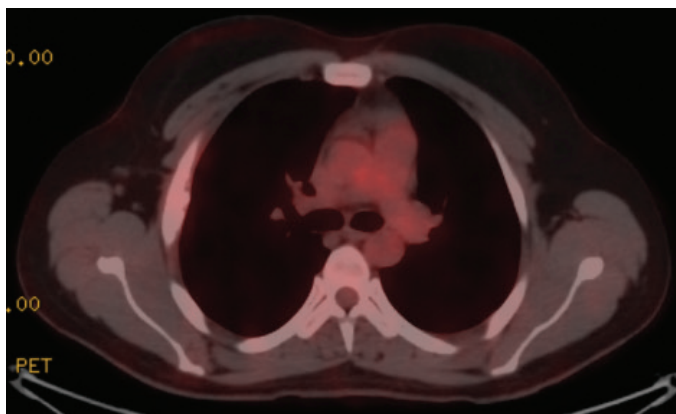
PET-CT, no increased activity
